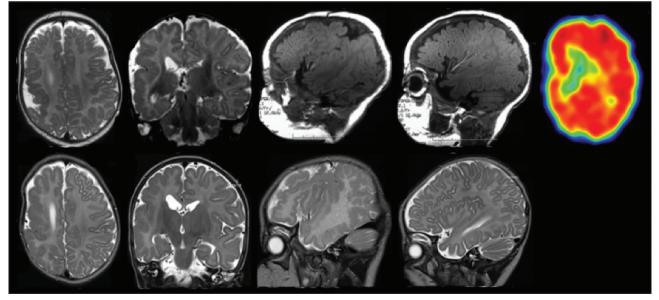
Brain magnetic resonance and FDG PET imaging of Case 1 (upper row) and Case 2 (lower row). MR images (from left to right) are axial and coronal T2, and sagittal T1 and T2 sequences. MR imaging shows extensive right hemispheric PMG, maximal in the perisylvian region along an abnormally extended and Sylvian fissue, and extending well into the frontal, parietal, and temporal lobes. The images fourth from the left of each row show the apparently normal contralateral left hemisphere with normal Sylvian fissure morphology and no evidence of PMG. An axial FDG PET image from Case 1 (upper right) shows significant right hemisphere hypometabolism, maximum in the right perisylvian and insular regions.
